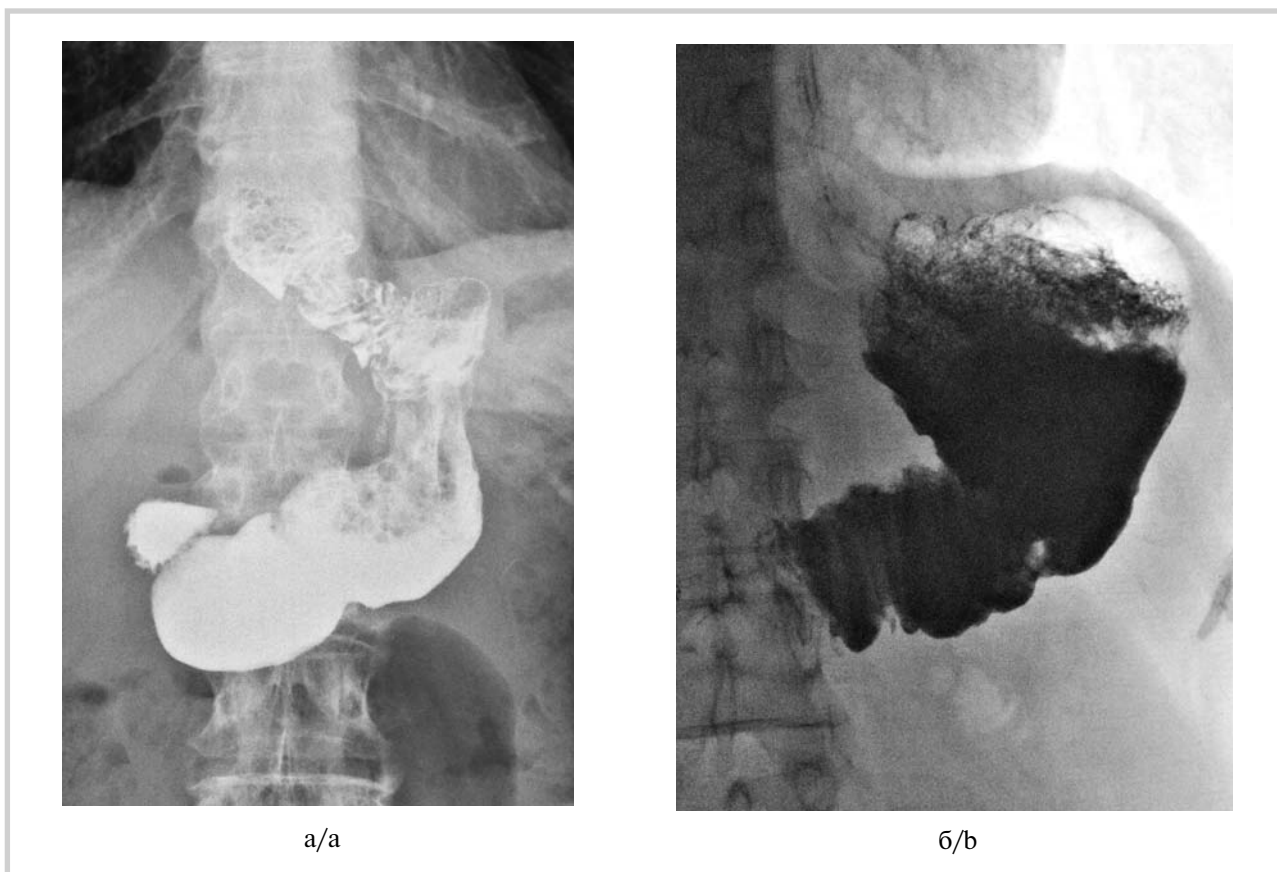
X-ray scans in the long-term period.
